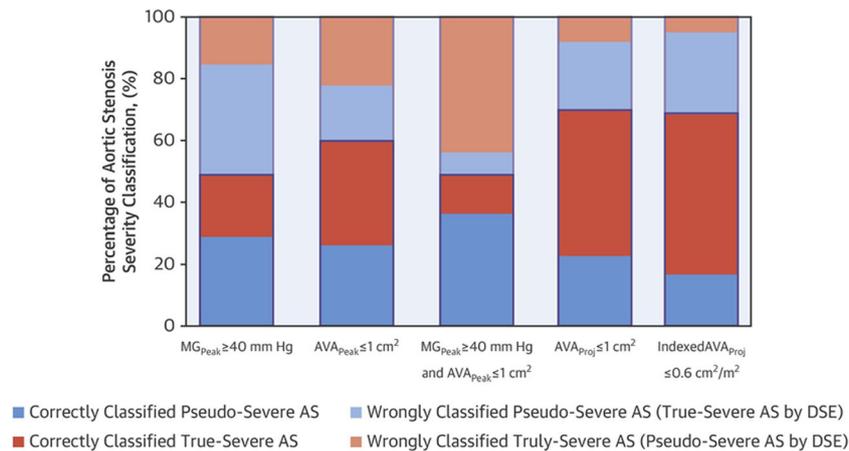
Comparison of the correct classification of AS severity according to DSE criteria in 87 patients with LF-LF severe AS with reduced LVEF. Patients with true-severe (orange) and pseudo-severe AS (blue) based on surgical or CT confirmation are shown with the percent correct (dark color) or incorrect classification (light color) by DSE criteria. AS =
